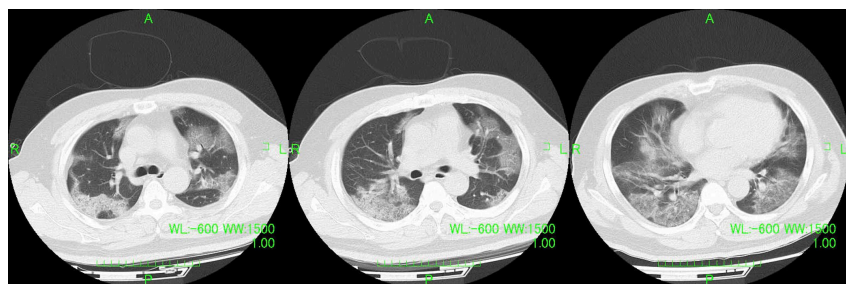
A CT of the patient's chest showed a ground glass shadow with dorsal peripheral dominance.
